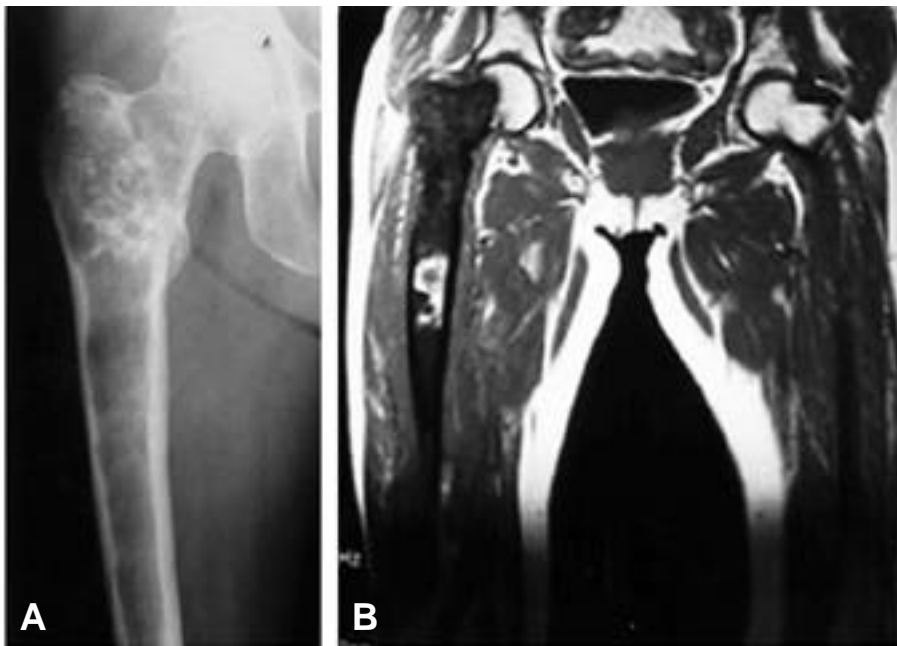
(A) Plain radiograph shows osteolytic lesion in proximal femur with amorphous calcification in femoral neck and intertrochanteric area. (B) MRI (T1 enhanced sagittal image) shows low SI on T1WI, high SI on T2WI and heterogenous enhancement and non-enhancing components suggesting chondroid or myxoid materials. No extra-medullary mass lesions or cortical disruption are seen.
